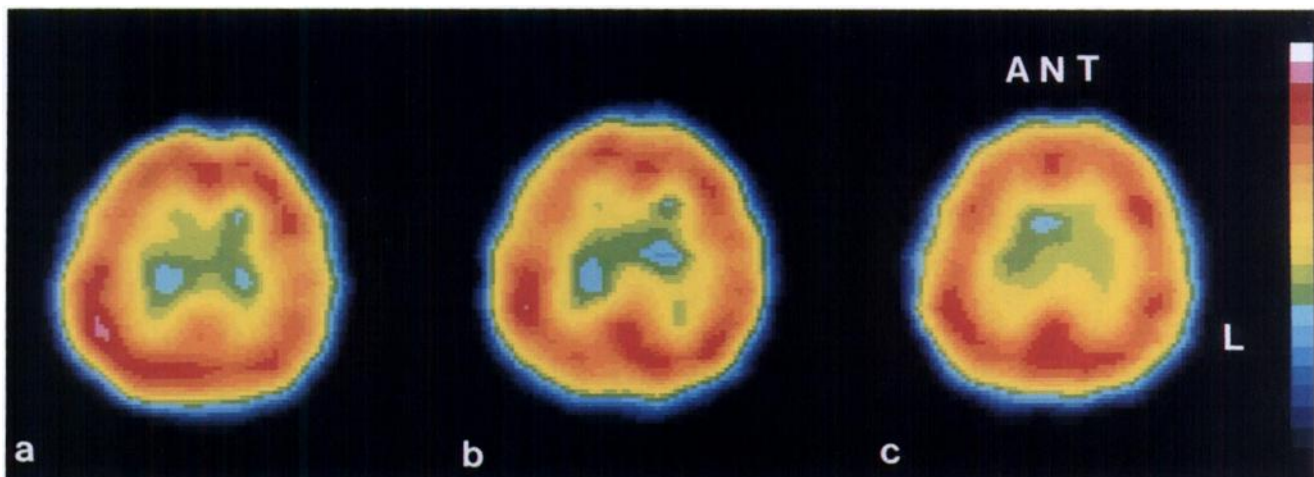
Technetium-99m-HMPAO SPECT images at the level of the MRI lesion show: (a) hyperperfusion in the right parieto-occipital area (3 days after the onset of symptoms), (b) remaining right parieto-occipital hyperactivity (1 mo later) and (c) a normal rCBF image (3 mo later).
